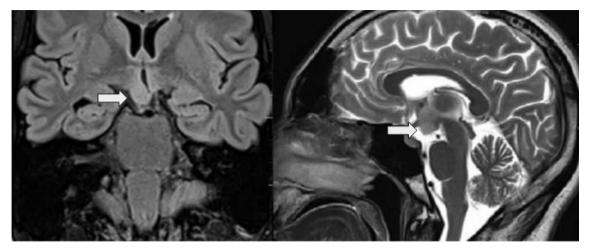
Coronal (FLAIR) and sagittal (T2W) sections of brain showing right hypothalamic hamartoma (marked in arrows). FLAIR, fluid-attenuated inversion recovery; T2W, T2 weighted.
